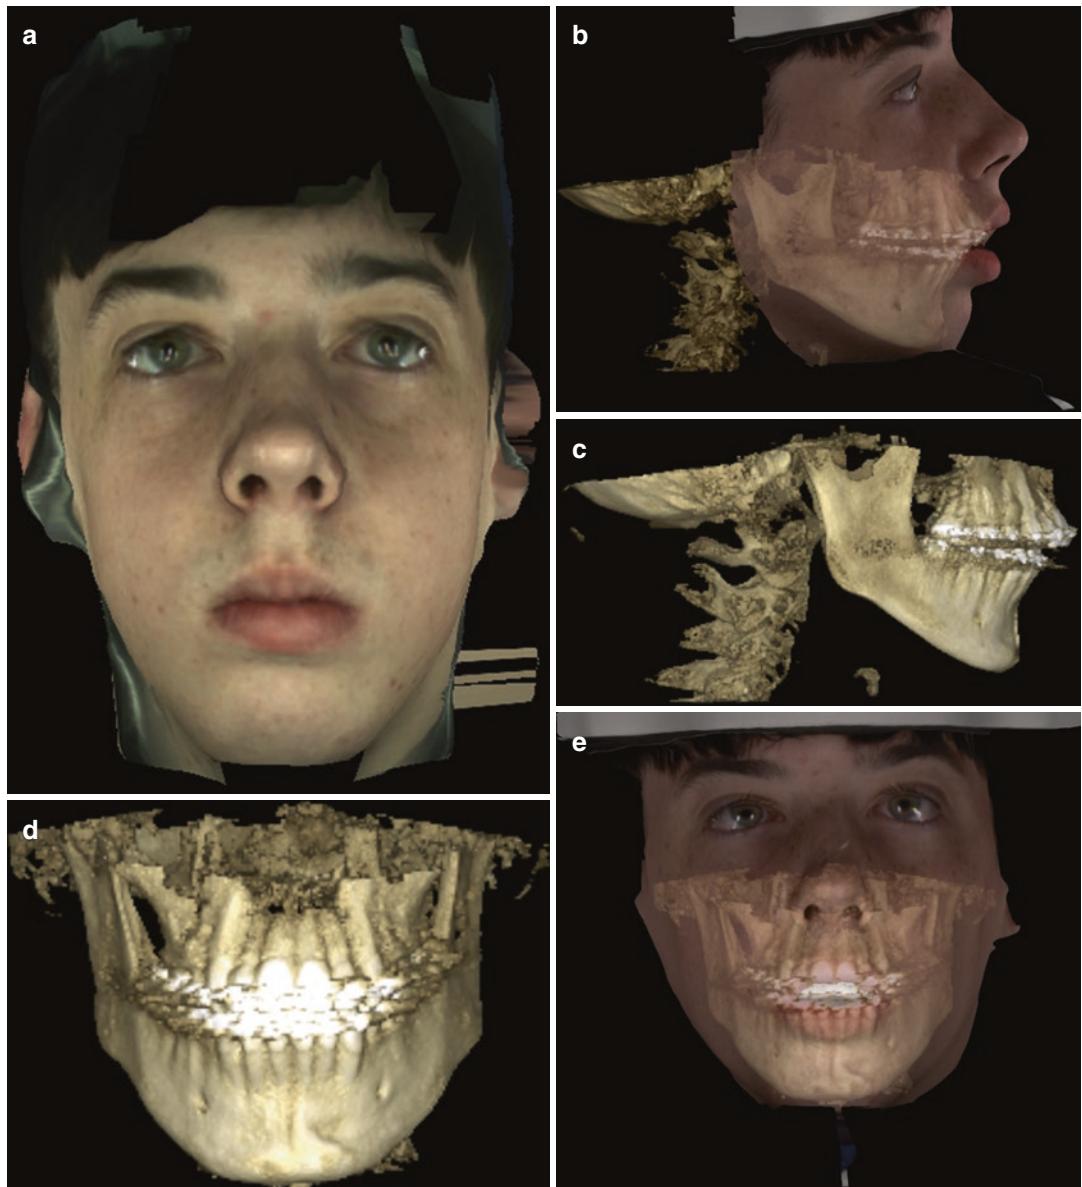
(a) 3D image created from a CBCT study showing soft tissue contours of a 17-year-old patient. (b–e) There are multiple degrees of adjustable soft tissue overlay which can be viewed on the patient's underlying facial skeleton
